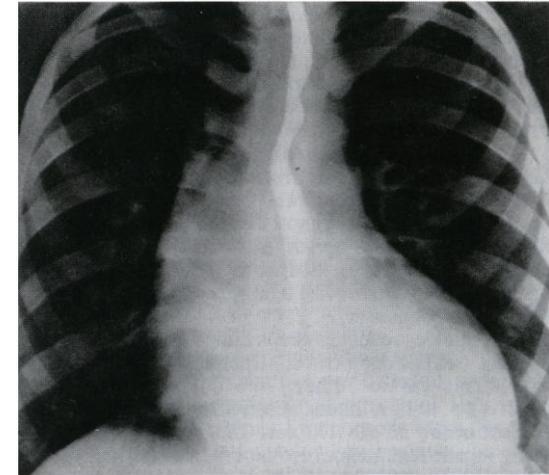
X-ray film of patient with coarctation of the aorta (posteroanterior view). Heart transverse size is significantly enlarged, heart waist is pronounced, there is contrasted esophagus shift on the level of pre- and poststenotic aortic dilatation ("reverse 3" sign).
